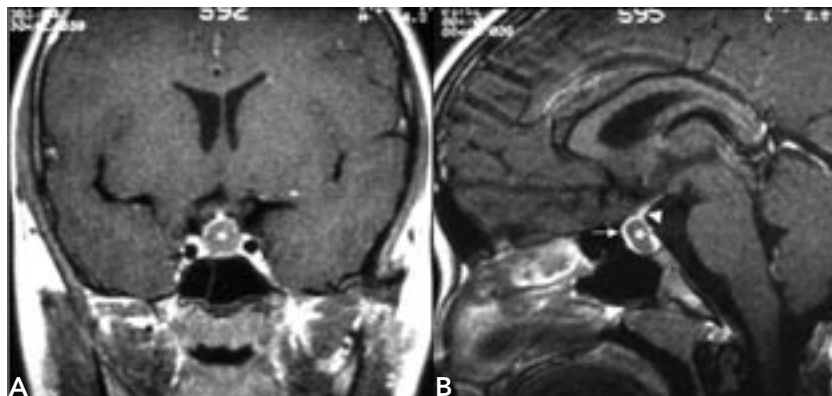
Sellar magnetic resonance imaging (MRI) of an intrasellar Rathke's cleft cyst (RCC), after iv administration of gadolinium-DTPA. Coronal (A) and sagittal (B) images. The cyst (\*) appears as a homogeneous lesion with low signal intensity and without post-contrast signal enhancement. The arrow shows the normal pituitary gland displaced forward by the cyst; the arrowhead points to the pituitary stalk.
